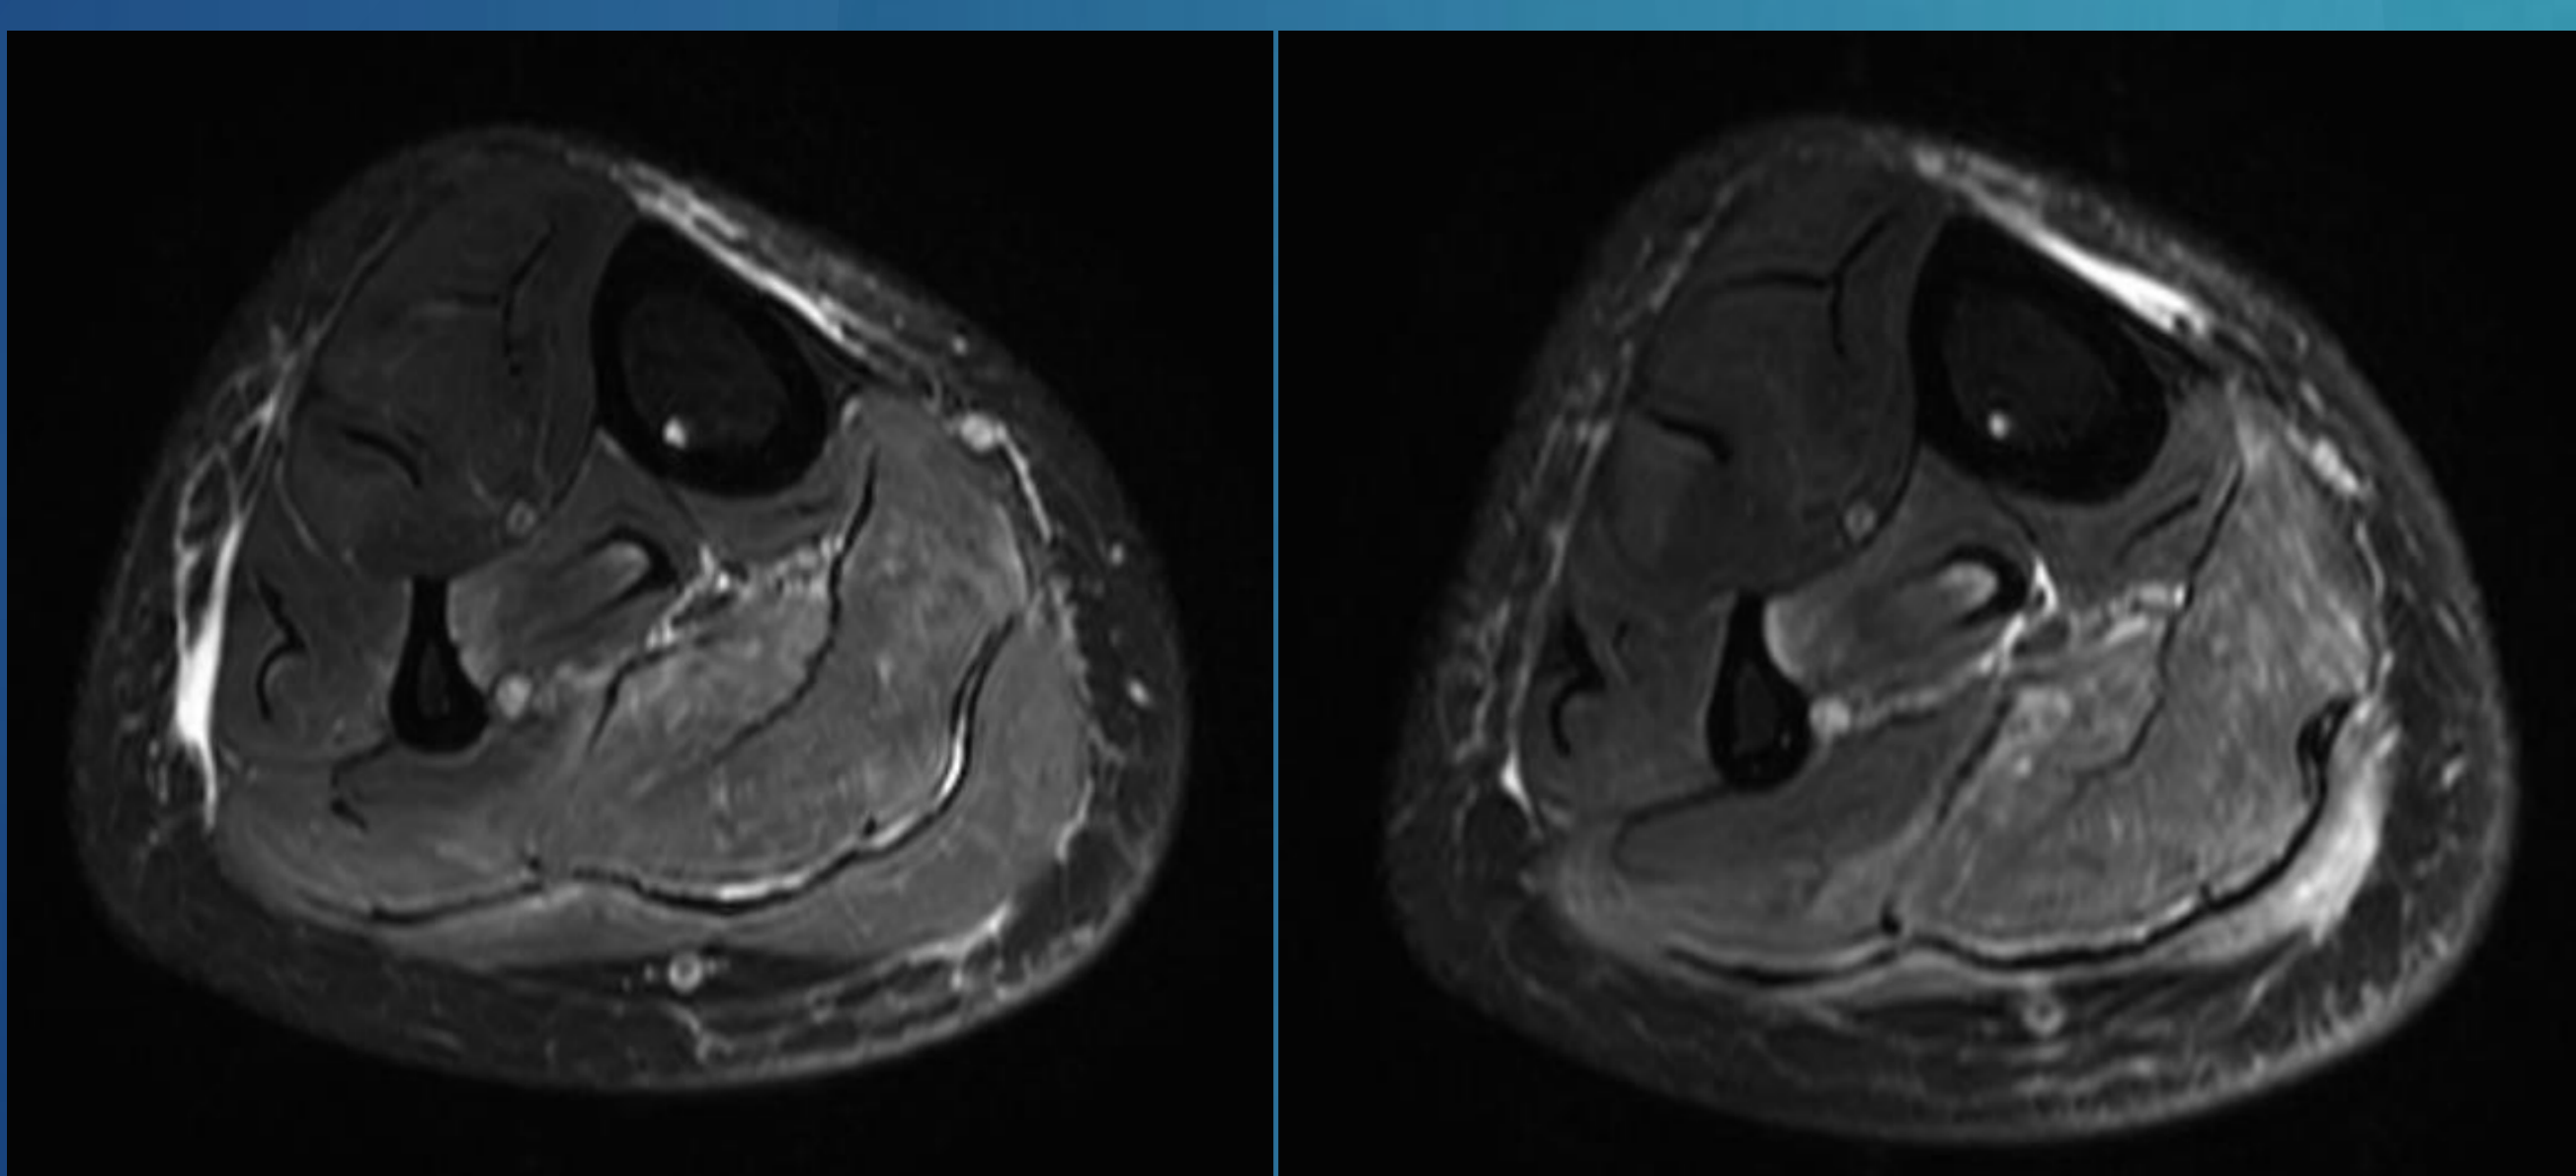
Axial T2-weighted MRI of right lower extremity(enhance). T2-weighted water-sensitive image shows diffuse feathery edema-like signal changes and perifascial edema in the posterior compartment muscles (soleus and gastrocnemius)
